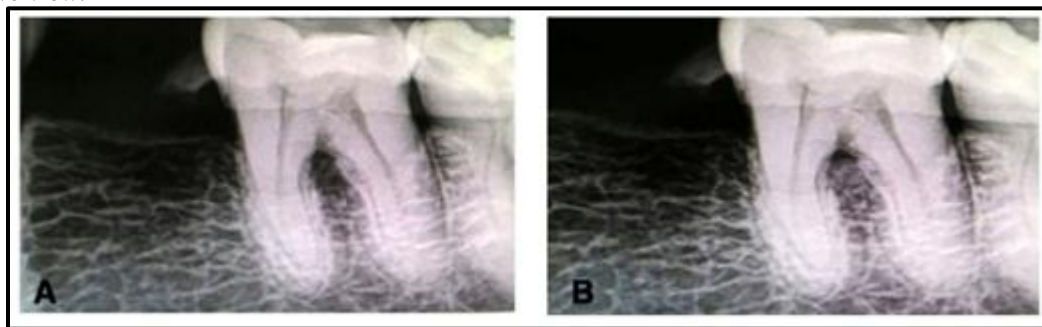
Radiograph: A) Base line B) After 6 months
